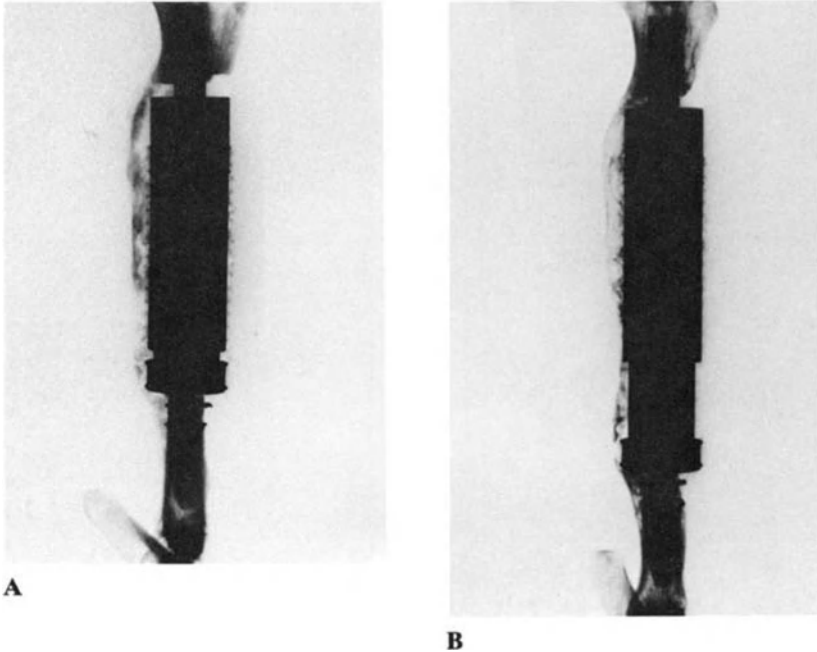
X-rays of the prosthesis. To the left of the prosthesis the bony bridge is visible. A: Before the first lengthening. B: After the last lengthening.
